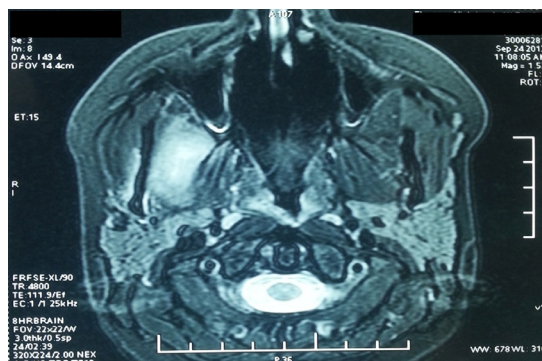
Magnetic resonance imaging of the patient that shows abscess formation in the infratemporal space.
